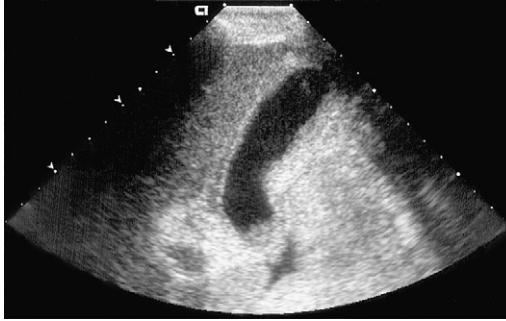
Gallbladder ultrasound of a patient with sepsis and cholestasis. A thick-walled gallbladder is visible with echogenic bile (sludge) within the neck of the gallbladder, but no stones. There is pericholecystic fluid (the echogenic [bright] area) near the neck of the gallbladder. A "halo" sign (intramural edema) is visible just to the left of the gallbladder in the image.
